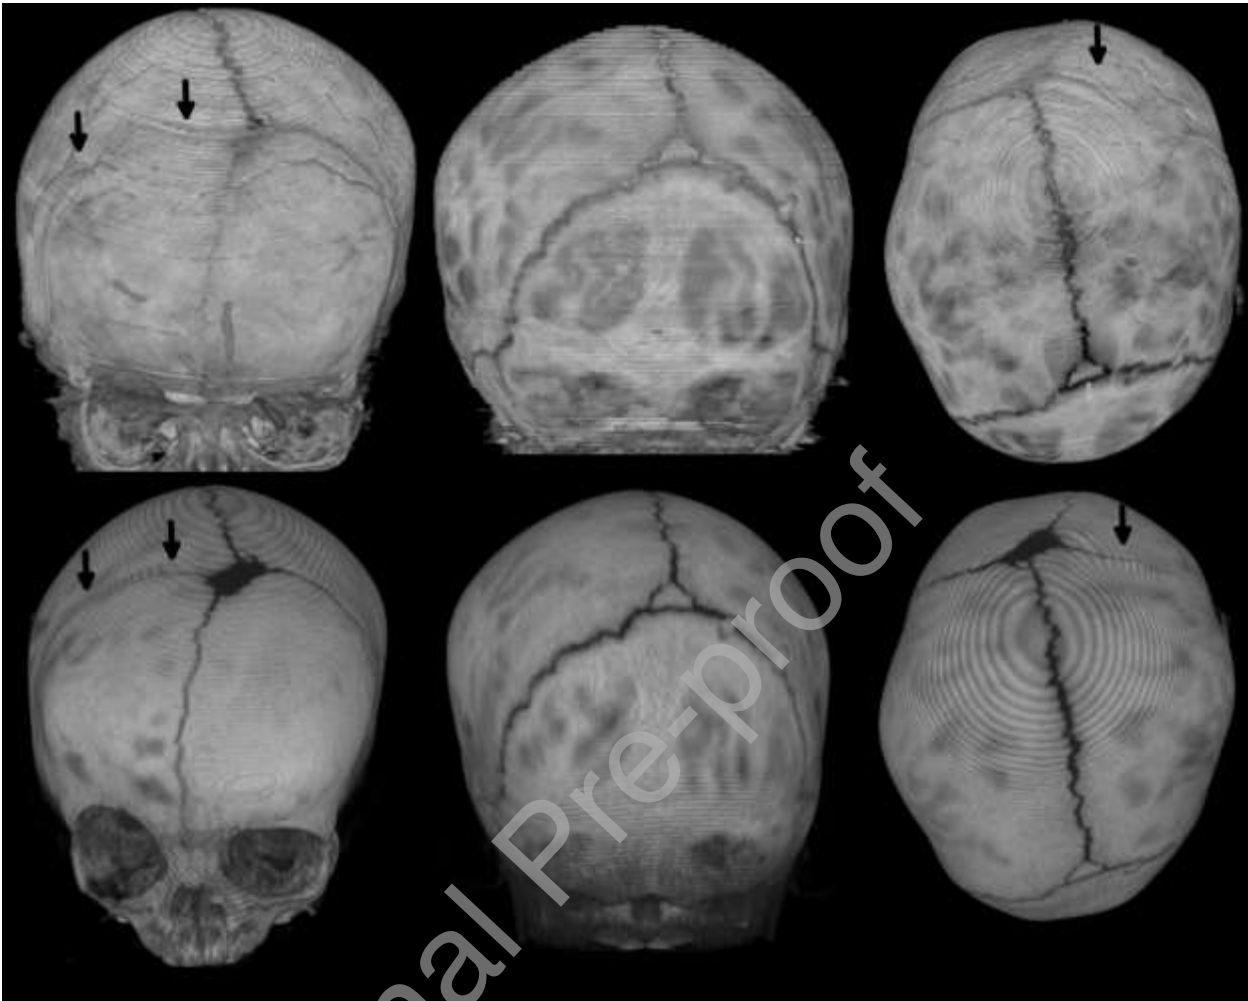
Skull images of patient 1 with right coronal synostosis. Top row, 3D-rendered BB-MRIs at the age of 7 months. Bottom row, 3D-rendered CT images of the same patient at the age of 6 months. The arrows point to the location of the fused suture.
